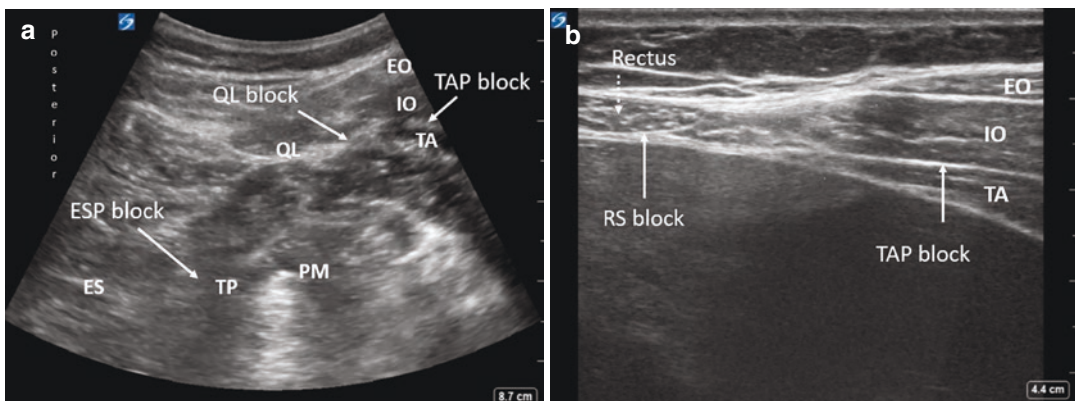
The ultrasound scanning of the posterior (a) and anterior (b) abdominal walls showing the site for Erector Spinae Plane (ESP), Quadratus Lumborum (QL), Transversus Abdominis Plane (TAP), and Rectus sheath
